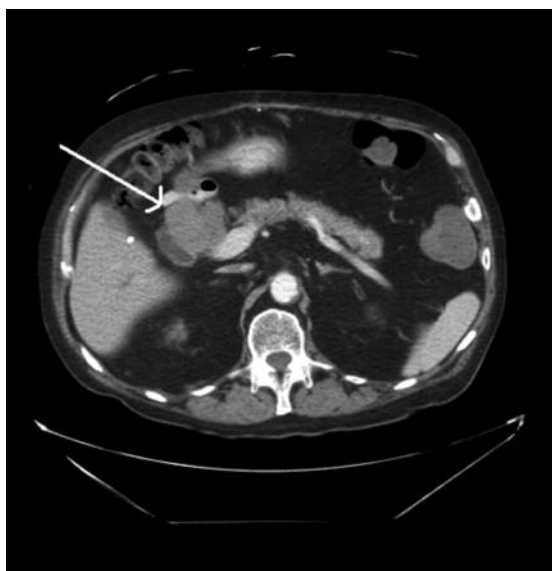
Peripancreatic mass is shown in upper abdominal CT scan.
